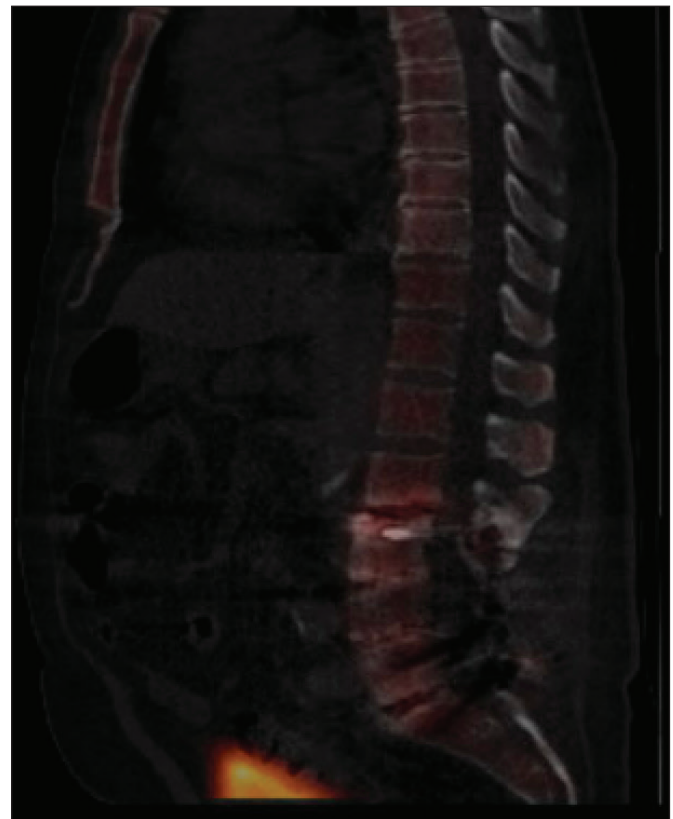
70-year-old Male with a history of L3-L4, L4-L5, and L5-S1 TLIF. MRI demonstrated multiple-level degenerative disease. His SPECT CT demonstrated activity at the L2-L3 disc space. He subsequently had L2-L3 extension TLIF. Subsequently, pain improved from a 6 at his baseline consult visit to a 2 at 6 months follow.
